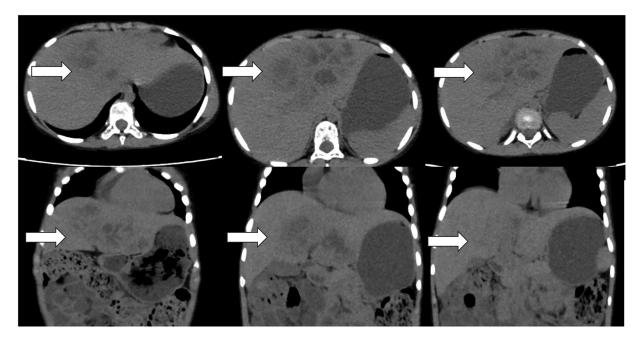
Axial (first row) and coronal (second row) non contrast CT images of the abdomen showed an ill-defined hypodense lesion in the left lobe of the liver. No calcifications were seen.
